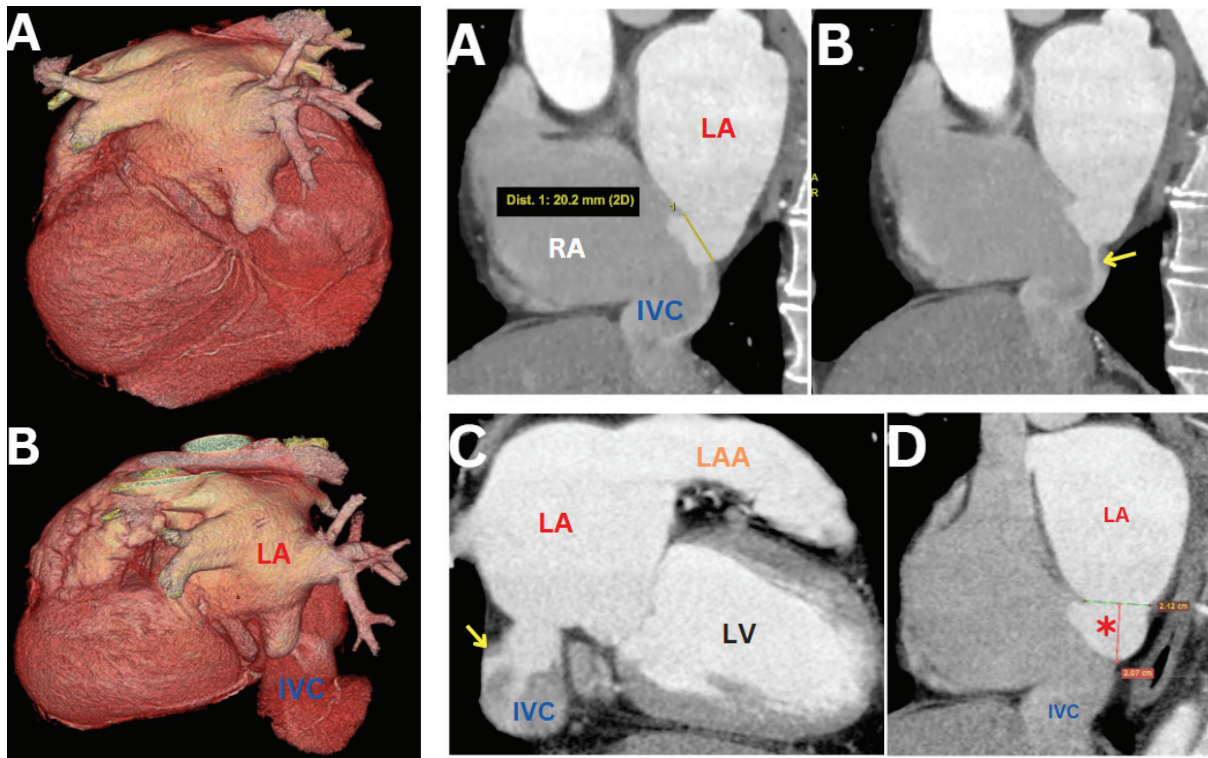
The inferior sinus venosus atrial septal defect (ASD), along with aneurysmal dilatation of the left atrial (LA) floor, is clearly visualized on Volume Rendering Technique (VRT) reconstructions from multislice cardiac computed tomography angiography (IVC - inferior vena cava) (A) caudal-posterior-left oblique view.(B) cranial-posterior-left oblique view)
